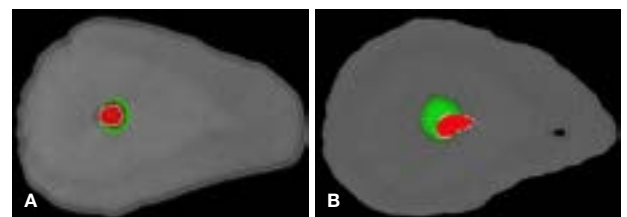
A representative Micro Computed Tomography example of a curved mesio-buccal root canal system, 1mm from the apical foramen. The canal was prepared with a Primary WaveOne Gold instrument (25/08) (Dentsply Sirona). No canal transportation at the of the root canal occurred (Red: pre-instrumentation area, Green: effect of canal preparation with shaping instrument).
